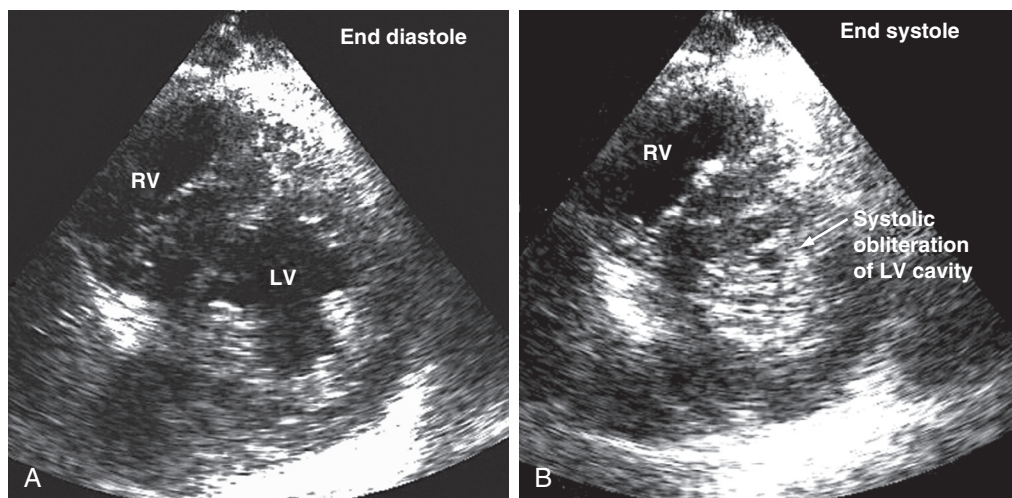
■ Systolic obliteration of the left ventricle (LV) in a patient with severe left ventricular hypertrophy and dehydration. This transthoracic parasternal short-axis view shows the left ventricle at end diastole (A) and at end systole (B). Nearly complete obliteration of the left ventricular cavity is seen at end systole. Systolic obliteration of the cross-sectional area accompanies decreased end-diastolic area and is considered to be a sign of severe hypovolemia. In this case, the patient presented with hypotension and was found to be severely dehydrated because of a viral gastroenteritis. RV, right ventricle.
